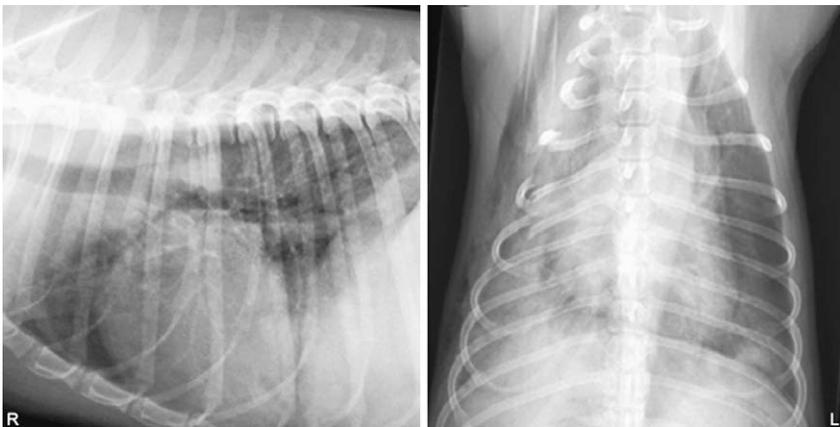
Orthogonal thoracic radiographs of a 2.5-year-old, neutered, female Jack Russell terrier with pulmonary contusions (hemorrhage) and rib fractures. The distribution of the lung lesions does not conform to any of the described distributions, as it is located in the entire right lung (both cranially and caudally) and focally in the left-caudal-lung lobe.
